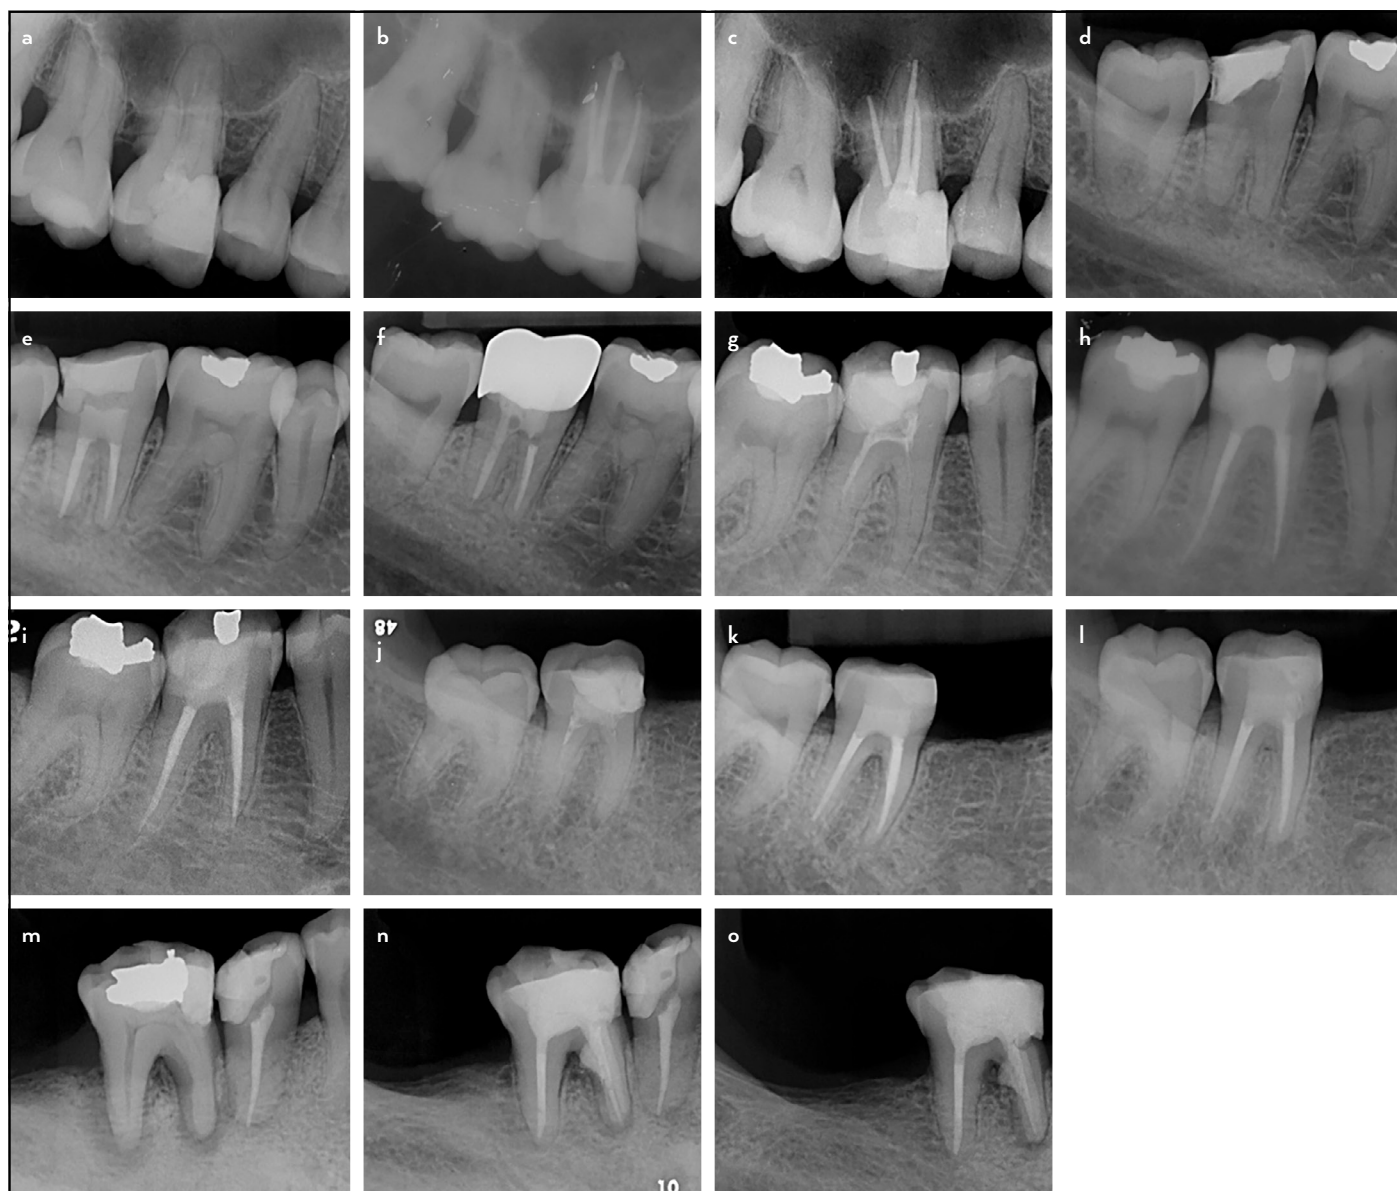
Treatment outcome assessment. (a–c) The preoperative radiograph (a) of the right maxillary first molar (tooth 16) showed normal apical tissues around the palatal root. The postoperative radiograph (b) revealed an apical perforation. At the 2-year follow-up (c), the periapical structures remained normal, and the outcome was classified as “healed.” (d–f) The preoperative radiograph (d) of the right mandibular second molar (tooth 47) showed an apical lesion at the distal root. A postoperative radiograph (e) revealed an apical perforation. At the 6-year follow-up (f), the apical tissues appeared normal, and the outcome was classified as “healed.” (g–i) The preoperative radiograph (g) of the right mandibular first molar (tooth 46) showed normal apical tissues at the mesial root. A lateral perforation was identified in the postoperative image (h). At the 3-year follow-up (i), the periapical structures remained normal, and the outcome was classified as “healed.” (j–l) The preoperative radiograph (j) of the right mandibular second molar (tooth 47) showed an apical lesion at the mesial root. A lateral perforation was evident in the postoperative image (k). At the 4-year follow-up (l), lesion progression resulted in the classification of the outcome as “disease.” (m–o) The preoperative radiograph (m) of the right mandibular first molar (tooth 46) revealed a periradicular lesion involving the furcation and apical region of the mesial root. A strip perforation was evident in the postoperative image (n). At the 3-year follow-up (o), persistence of the radiolucency led to the classification of the outcome as “disease”.
